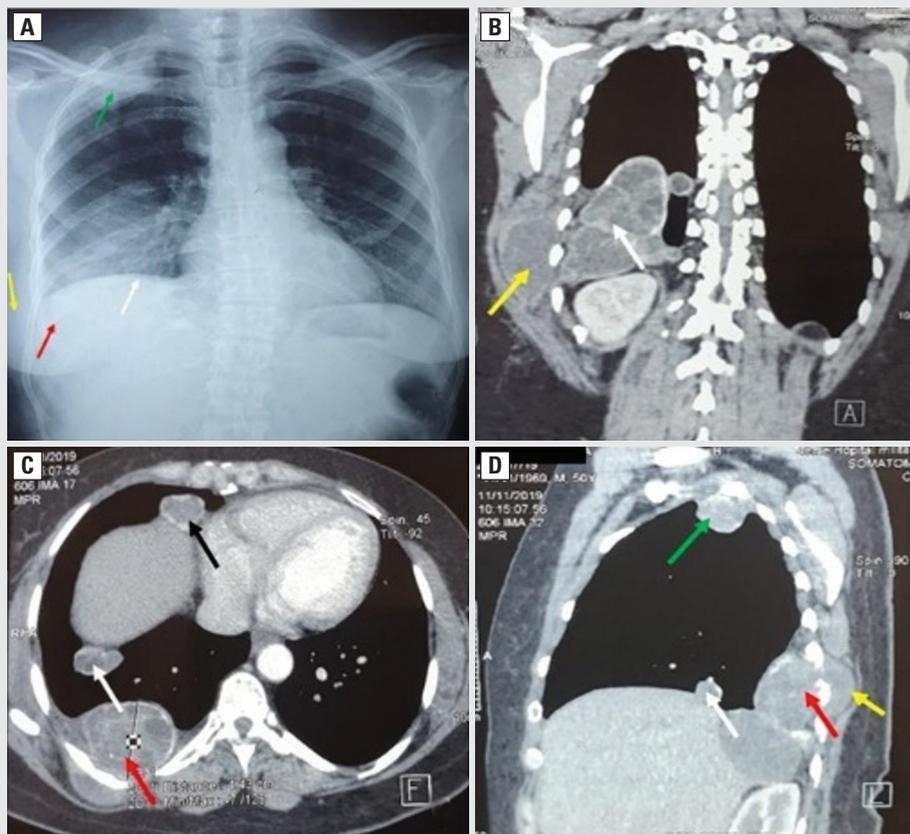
A. Chest x-ray showing multiple right thoracic opacities; B–D. Chest computed tomography showing multiple right thoracic hydatid cysts: chest wall (yellow arrow), diaphragmatic (white arrow), pericardial (black arrow), pleural (red arrow), and pulmonary (green arrow) regions
